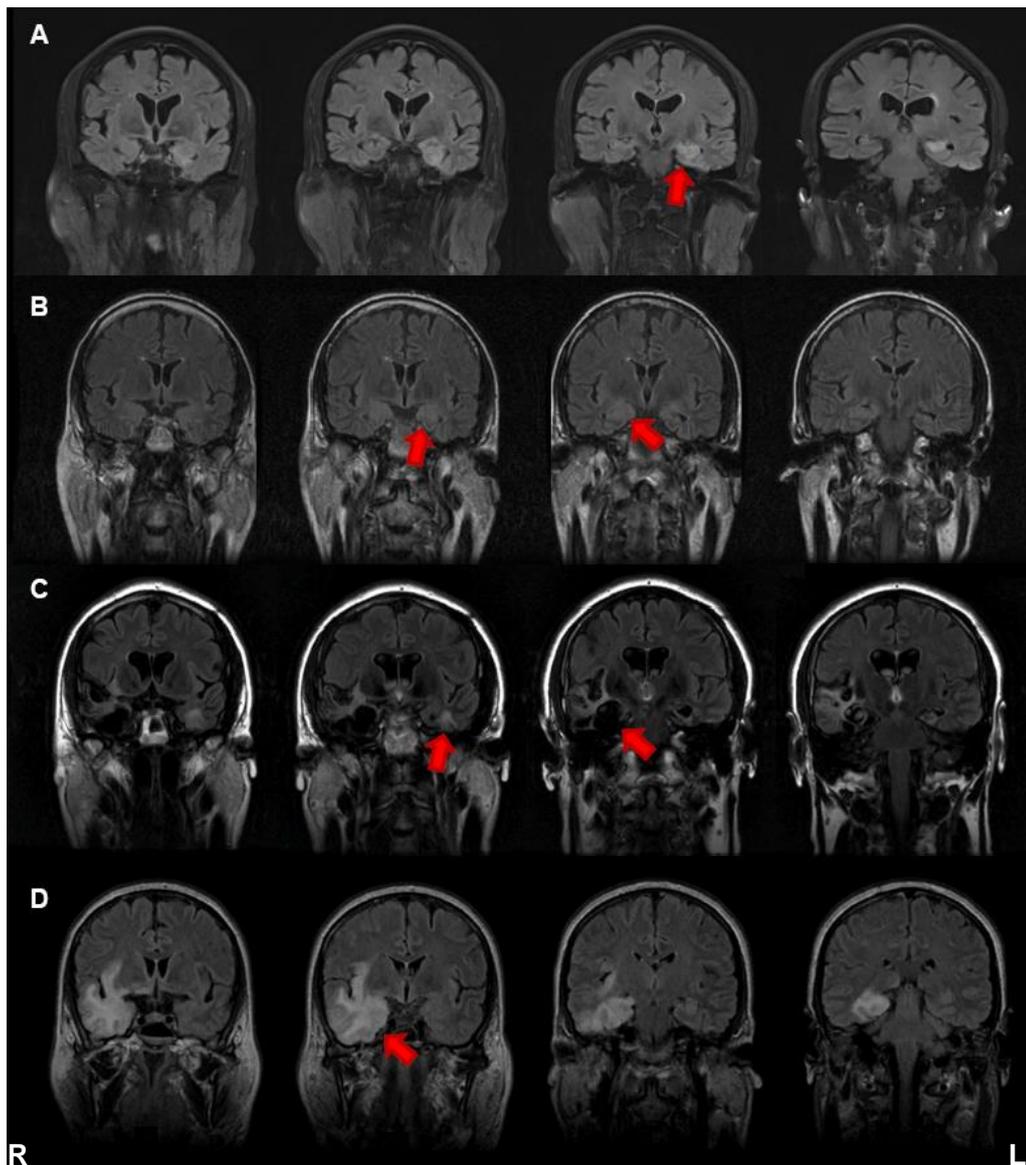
Coronal FLAIR MRI showing patients' lesions (red arrows).
